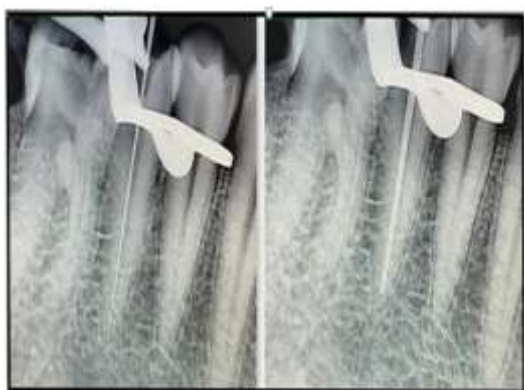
Working length determination followed by master cone radiograph
